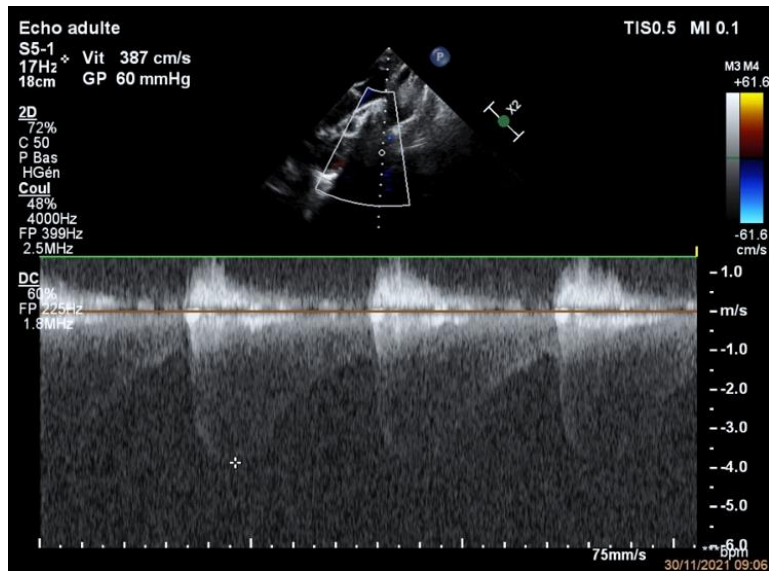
Cardiac ultrasound, suprasternal section with continuous Doppler: systolic isthmic gradient with diastolic extension.
